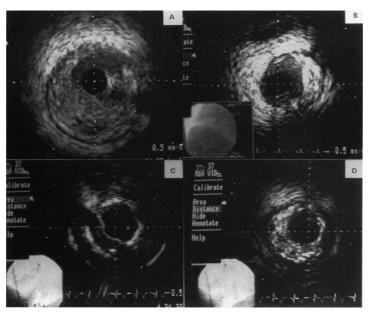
Angioscopic images of the types of ultrasound-derived lesions: (A) plaque with poorly echo-reflective tissue between 4 and 9 o'clock, (B) plaque with highly echo-reflective tissue with eccentric location between 1 and 4 o'clock, (C) plaque with highly echo-reflective tissue with shadowing, and (D) mixed plaque composed of poorly echo-reflective tissue at 6 to 11 o'clock and highly echo-reflective with shadowing at 1 to 5 o'clock.
